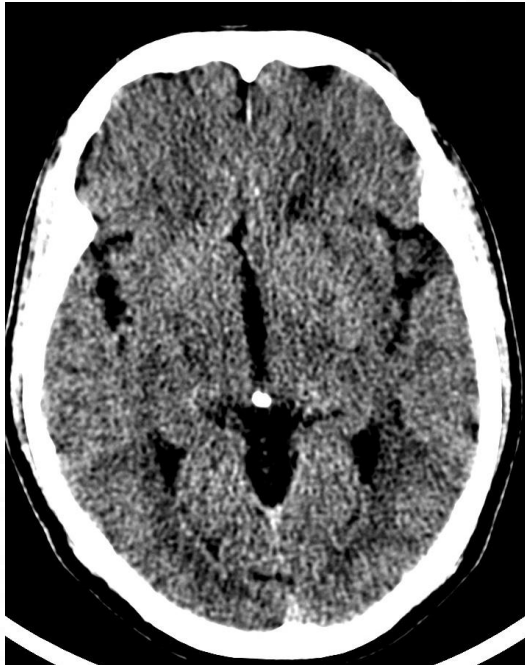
Plain CT (ASPECTS 5)
